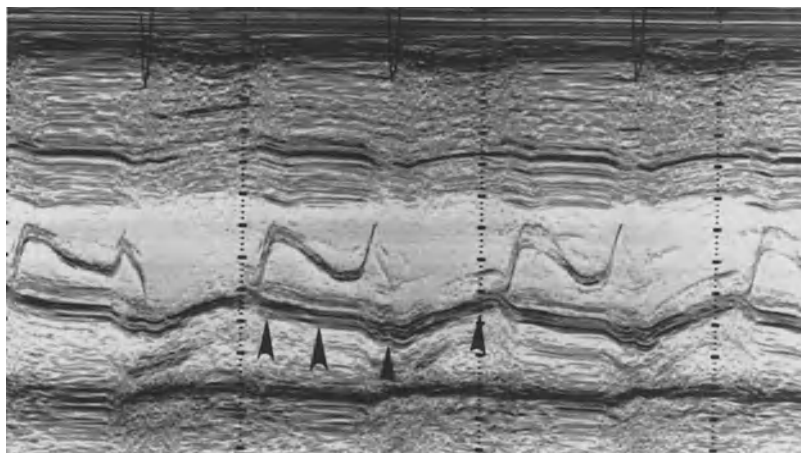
M-Mode echocardiogram showing mitral annular calcification (arrows) with space behind this resembling pericardial effusion.
